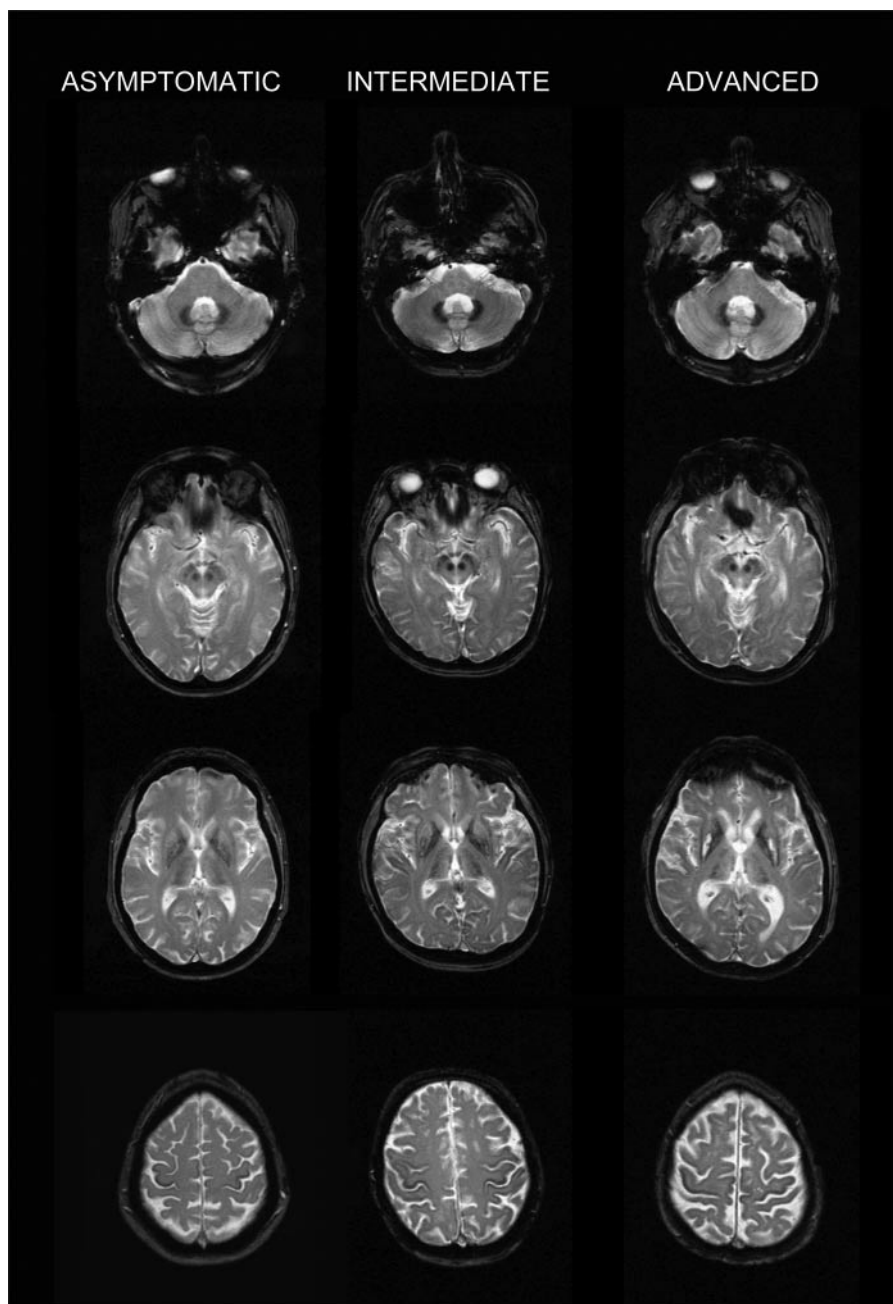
Brain magnetic resonance imaging in neuroferritinopathy. *Left hand images:* asymptomatic subject (Case 1, who had predictive testing and harboured the 460InsA *FTL1* mutation). Profound signal loss is noted on T_2^* imaging in red nuclei, substantia nigra and globus pallidus, with less marked loss in dentate nuclei, thalami, putamen, caudate nucleus head, and precentral gyrus. Abnormalities are inconspicuous on T_2 , except for minor low signal in red nuclei and substantia nigra. *Middle images:* intermediate case (Case 12). T_2^* signal loss is present in the same locations, but also within the internal capsules, and more prominently within the dentate nuclei and thalami. T_2 now shows signal abnormality in the lentiform and caudate nuclei, particularly focally in the globus pallidus and posterior putamen, mirroring areas of high signal on T_1 (indicative of mineral deposition). *Right hand images:* advanced case (Case 35). The pallidal lesions have now undergone internal cystic degeneration. There is involuntional change, and there are several small vessel ischaemic lesions present.
